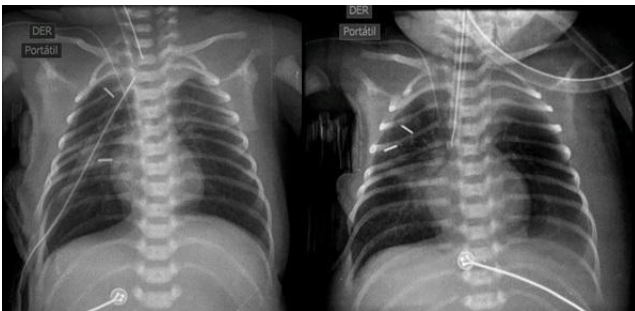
Radiographs were conducted daily to monitor the narrowing of the gap by the approximation of the titanium clips
